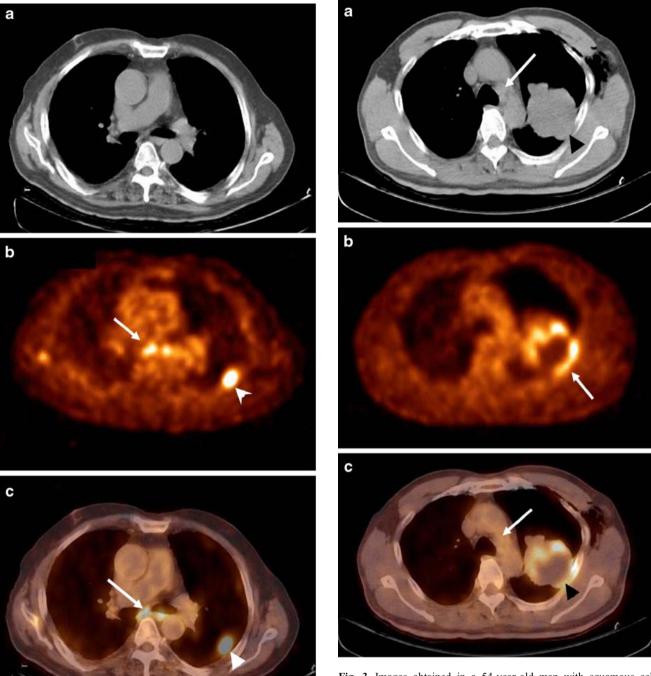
Images obtained in a 69-year-old man diagnosed with large-cell carcinoma in the left upper lobe. a CT image shows a small lymph node in the subcarinal area but because of its small size, metastasis was excluded. b PET image shows increased glucose metabolism in the mediastinum (*arrow*) and left upper lobe (*arrowhead*). c Fused PET/CT image shows increased glucose metabolism in the subcarinal lymph nodes (*arrow*) and left upper lobe (*arrowhead*). After mediastinoscopic biopsy, lymph node metastases were found in the subcarinal lymph nodes
